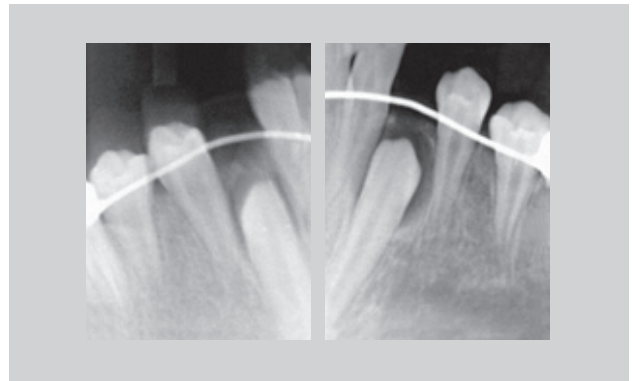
Radiographs showed radiolucencies passed beyond the cemento-enamel junction (CEJ). Periapical radiographs of teeth 22 (right) and 27 (left) are shown. Radiolucencies passed beyond the CEJ and no obvious resorption was noticed on adjacent teeth.
